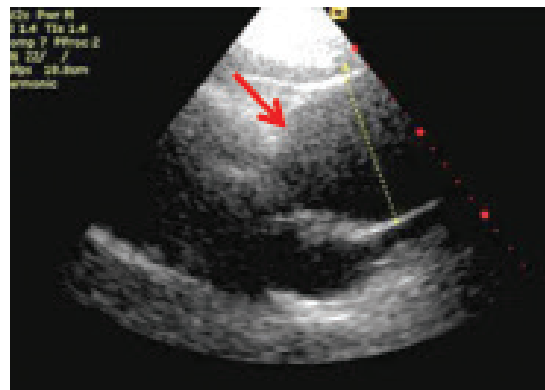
Transthoracic echocardiography (TTE) long parasternal view showing enlarged aortic root.
